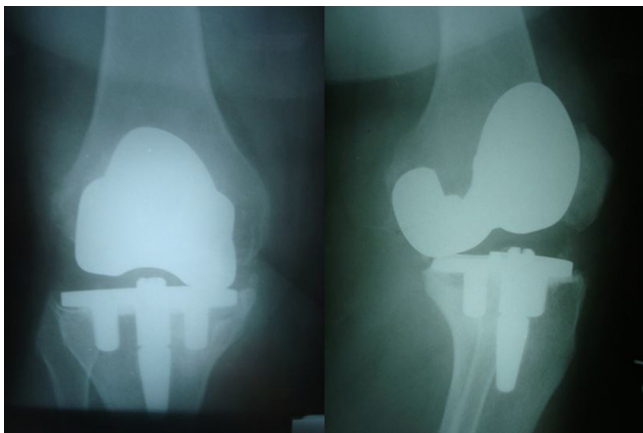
Preoperative AP and lateral radiographs.
